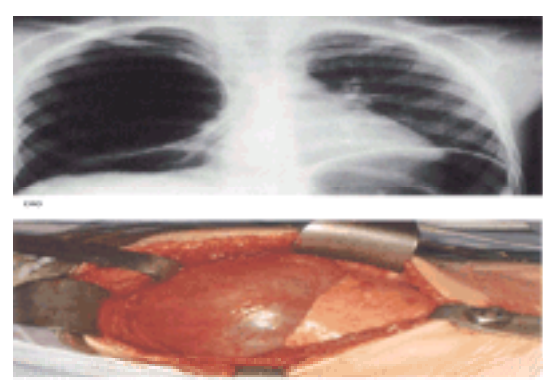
(a) Chest radiograph obtained because of croup in a 4-year-old female. It revealed a large air-filled pulmonary cyst occupying at least half of the hemithorax. (b) Operative findings of a large thin-walled air-filled cyst within the right upper lobe. A limited amount of normal pulmonary parenchyma of the upper lobe was 'splayed' out over the superior surface of the cyst. Right upper lobectomy was performed.
